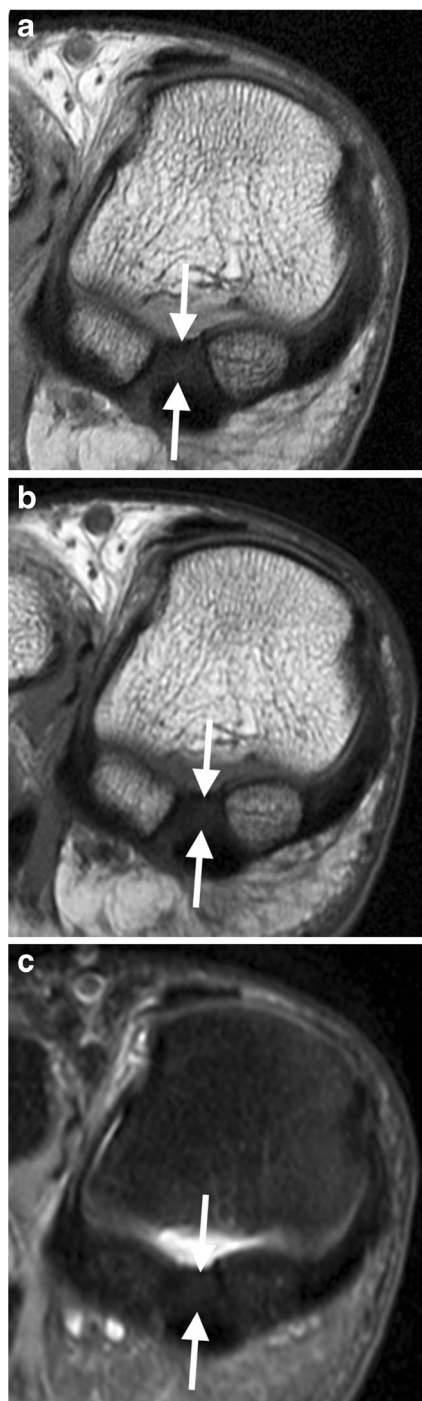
27-year-old male volunteer. Arrows indicate the visible inner and outer contour of the intersesamoid ligament. The demonstrated intersesamoid ligament is hypointense on intermediate-weighted (A) and T1-weighted (B) MR images. No hyperintense areas are visible on the transverse intermediate-weighted MR image with fat suppression (C)
